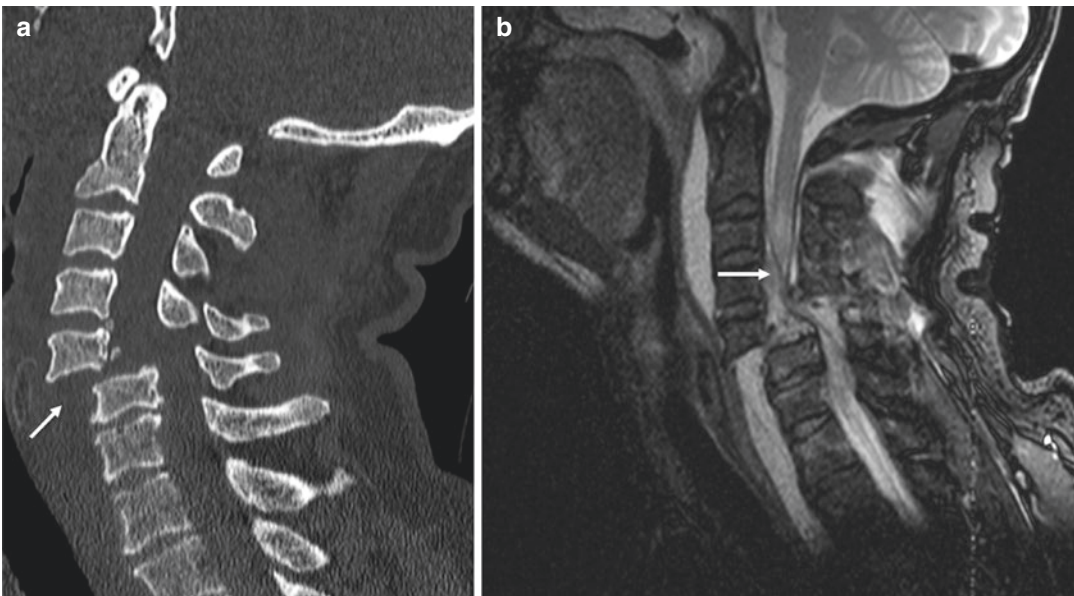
CT scan (a) and MR in sagittal views (b) in a patient with a severe cervical spine injury (a, arrow) and spinal cord transection (b, arrow)
